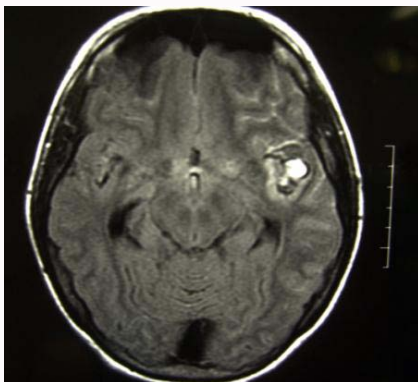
Brain MRI showing a heterogeneous lesion at left Sylvian fissure.
